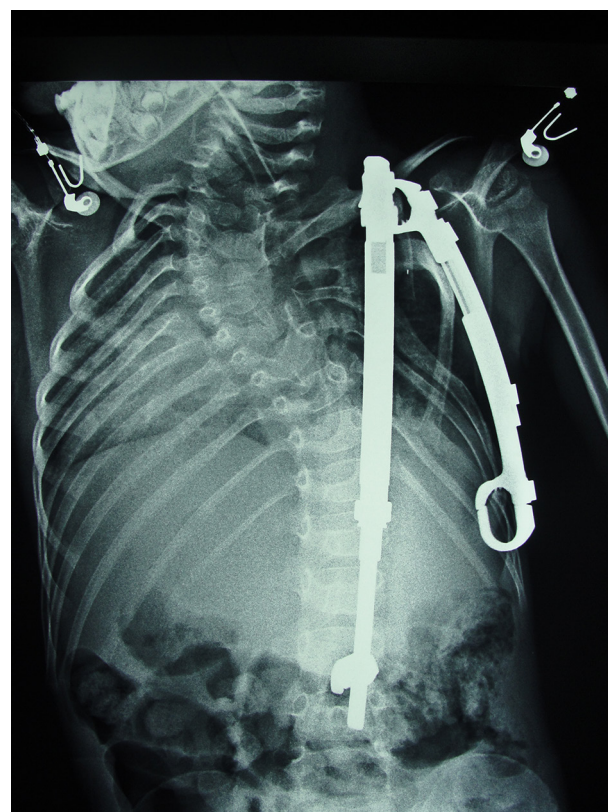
AP Radiograph of a 7-Year-Old Spondylocostal Boy Patient With a Rib to Rib and Rib to Spine VEPTR
